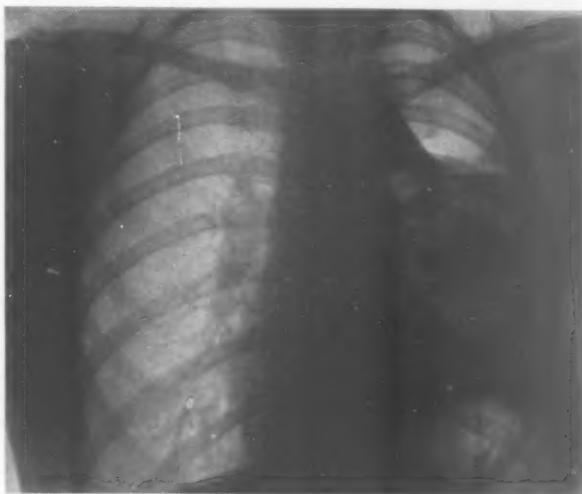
X-ray of chest taken August 1, 1927, about six weeks after operation, showing the beginning expansion of the lung.
